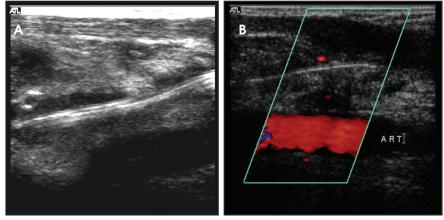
A 90-year-old man with left upper extremity erythema and swelling, 9 days following pacemaker placement. Gray scale (A) and color Doppler (B) coronal sonographic images demonstrate thrombosis of the left mid and distal subclavian vein around the pacemaker wire.
